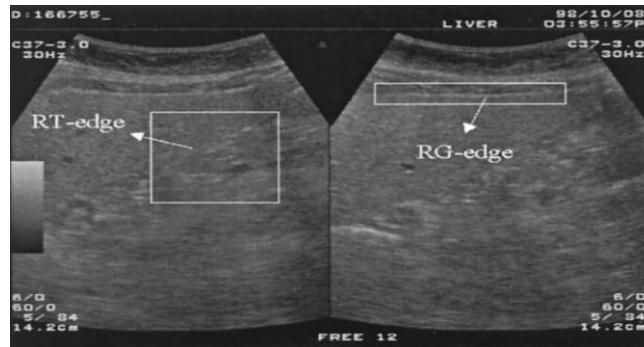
Ultrasound image showing the difference between the RG edge (left) and RT edge (right)
